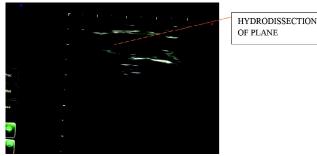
Ultrasonographic image of the drug spread
